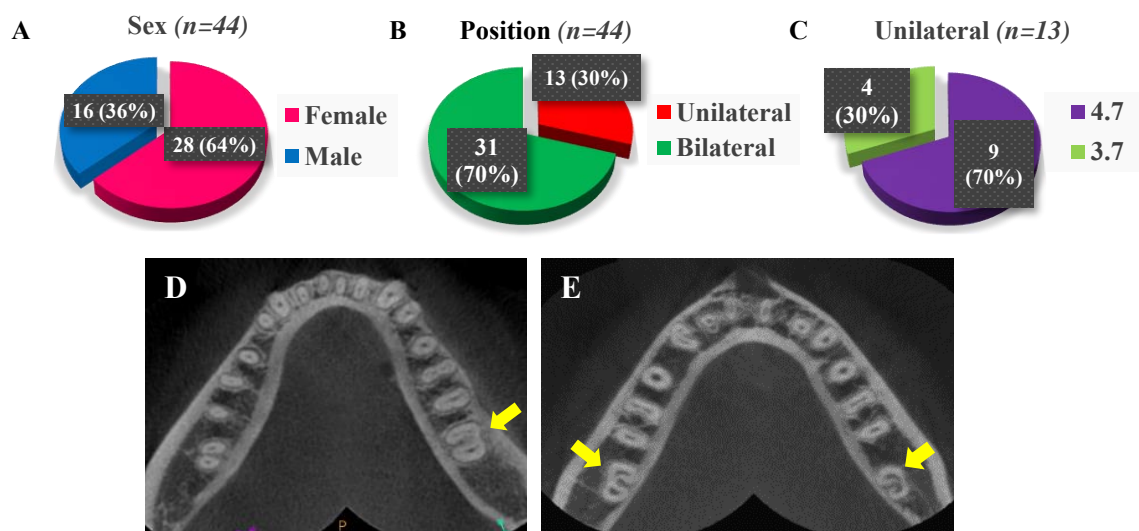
Prevalence of C-shaped canals according to (A) sex, (B) position, uni or bilateral and, (C) tooth 3.7 or 4.7, when were unilateral. CBCT axial slices in which the presence of unilateral (D) and bilateral (E) C-shaped canals is shown with yellow arrows.
